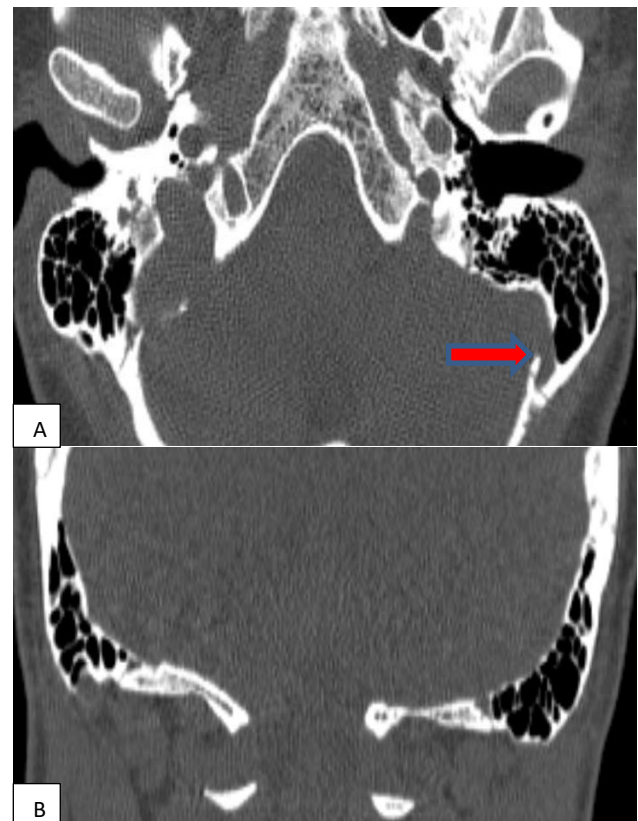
(A and B): HRCT temporal bone-axial view-showing thinning and erosion of medial wall of left mastoid sinus (Red arrow) and coronal view-thinning of medial wall of left mastoid sinus.
